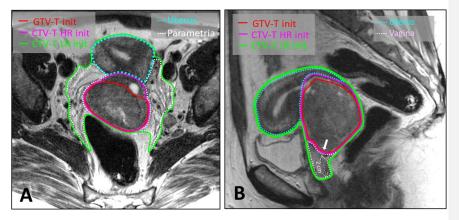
(A) Delineation of CTV T LR MRI on axial slice of pelvic T2w FSE MRI in a cervix cancer patient with a large T2B primary tumor. Components of CTV T LR MRI are depicted (GTV T init, CTV T HR init, uterus and parametria). (B) The principle of inclusion of uninvolved vagina into CTV T LR MRI is demonstrated: lowermost border of the CTV T HR init is identified (solid arrow). From this point, CTV T LR contour is extended for 2 cm along the vaginal axis. In practice, there is no need to delineate the parametria, uterus and vagina as individual sructures; CTV LR init contour should encompass all these regions (green contour).
